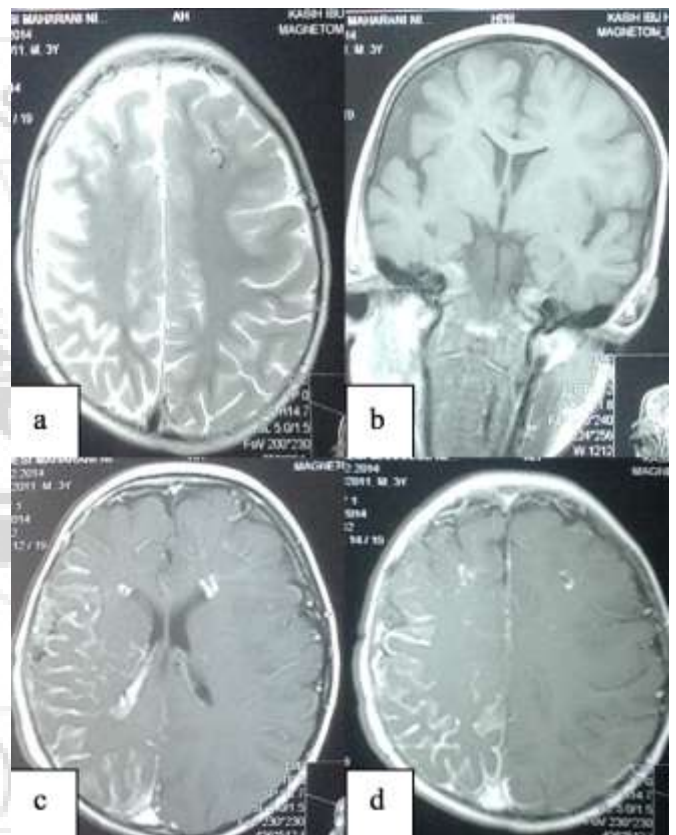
a. MRI revealed abnormal calcification on bilateral frontal sub-cortical area and asymmetric right fronto-temporo-parietal area. b. cerebral atrophy on asymmetric right fronto-temporo-parietal area. c and d. MRI with Gadolinium contrast revealed prominent leptomeningeal angiomas.
